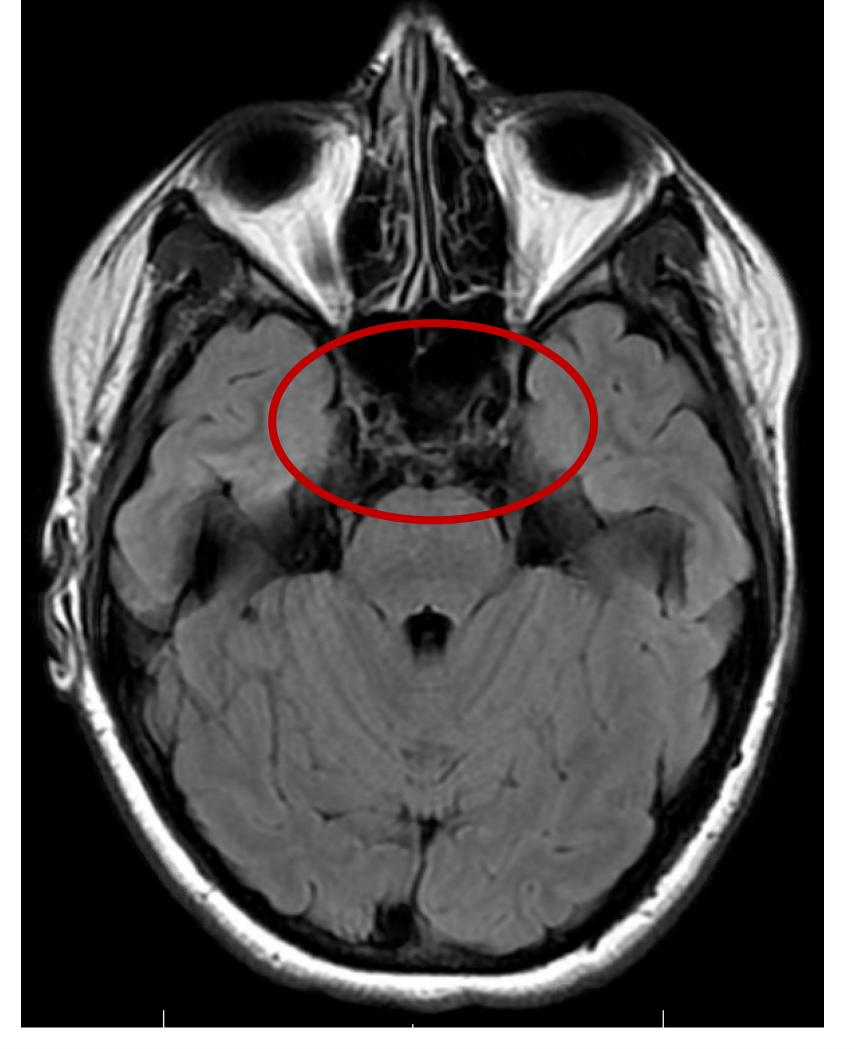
Follow up MRI brain T1 post contrast (*left*) and T2-FLAIR (*right*) showing improvement in the caliber of the cavernous sinus and right internal carotid artery inflammation.
